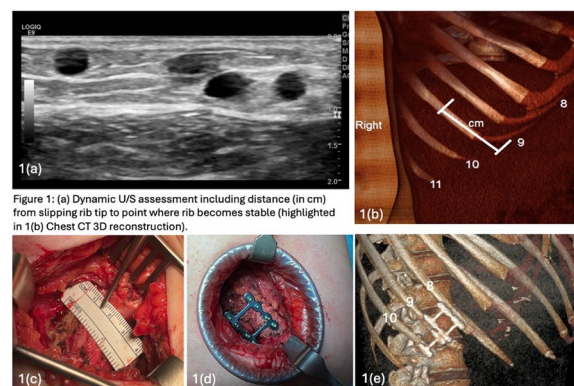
(a) Dynamic U/S assessment including distance (in cm) from slipping rib tip to point where rib becomes stable (highlighted in 1(b) Chest CT 3D reconstruction).
